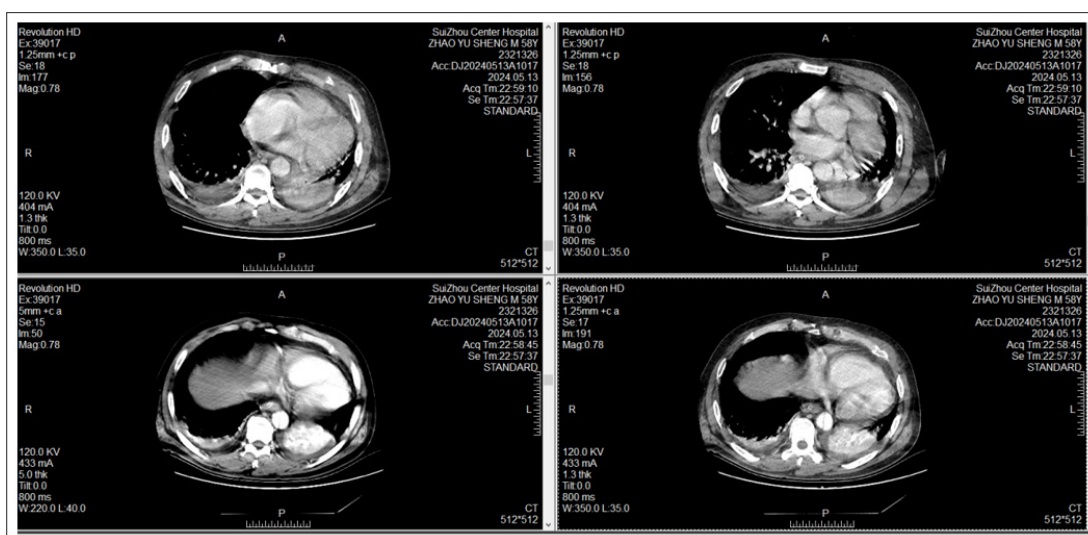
CTA+ 3D reconstruction + 3D imaging of the thoracic and abdominal aorta on May 13 showed that aortic dissection (type III), the abdominal cavity may stem from the false lumen, the right renal artery may originate from the true lumen, the superior mesenteric artery and the left renal artery straddle the true and false lumen, the slightly low density shadow around the superior mesenteric artery was considered to be interwall hematoma, the aortic arch changes were considered to be ulcerated, and small ulcers formed at the beginning of the descending aorta. Please consider clinical review. Atherosclerosis of abdominal aorta, bilateral common iliac artery and internal iliac artery. Cardiothoracic vascular surgery and interventional consultation should be given temporary anticoagulation treatment.
